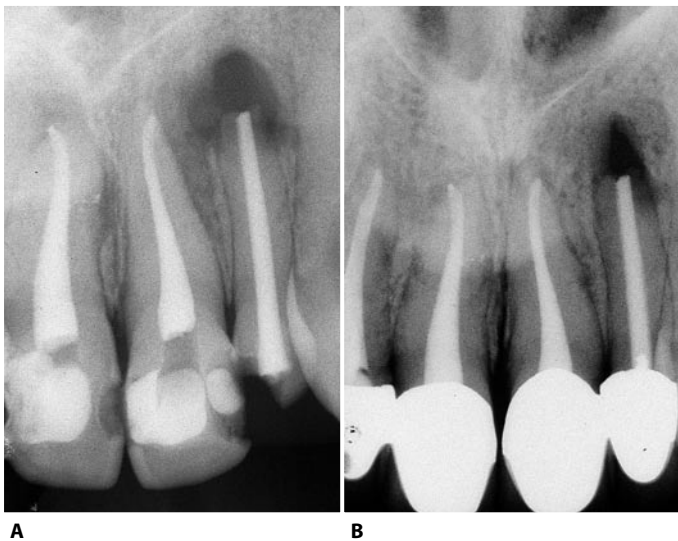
A. Postoperative radiograph of the upper central incisors: the shaping totally respects the endodontic anatomy. The left lateral incisor, in contrast, had been treated previously, without taking into consideration the anatomy of the endodontium, so as to reproduce the shape of the instruments within the root canal. B. Recall radiograph 18 months later.
